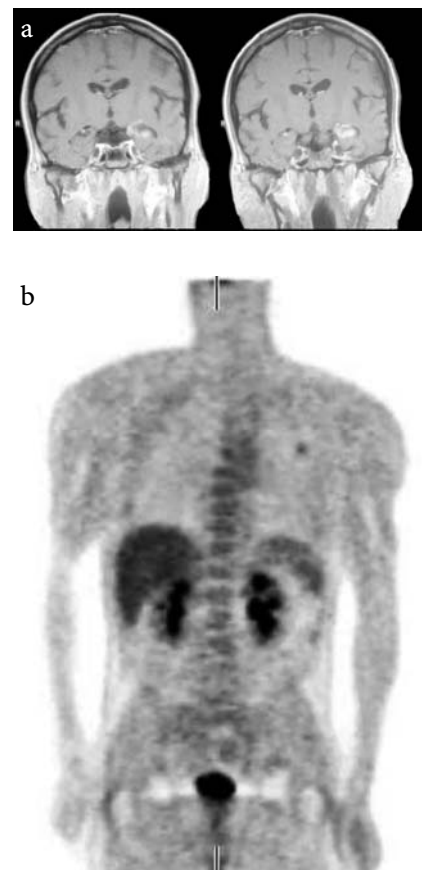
a T1-weighted MRI in the coronal plane showing a contrast enhancing lesion in the left hippocampal formation. b Whole-body FDG-PET scan; coronal plane. Circumscribed, pathologically increased glucose metabolism in the left superior pulmonary lobe. Correspondingly, thoracic CT showed a hyperdense lesion of 1.6 cm, suspicious of a peripheral lung carcinoma (not shown)
